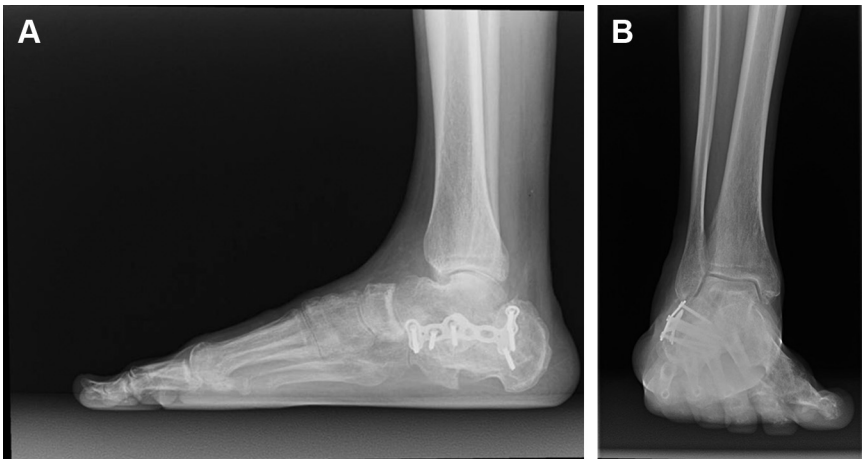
(A) Preoperative weight-bearing lateral radiograph. (B) Preoperative weight-bearing mortise ankle radiograph. Note the overlap of the midfoot on the talus, indicating a flattened talus. This patient also has a widened heel and resultant subfibular impingement.
